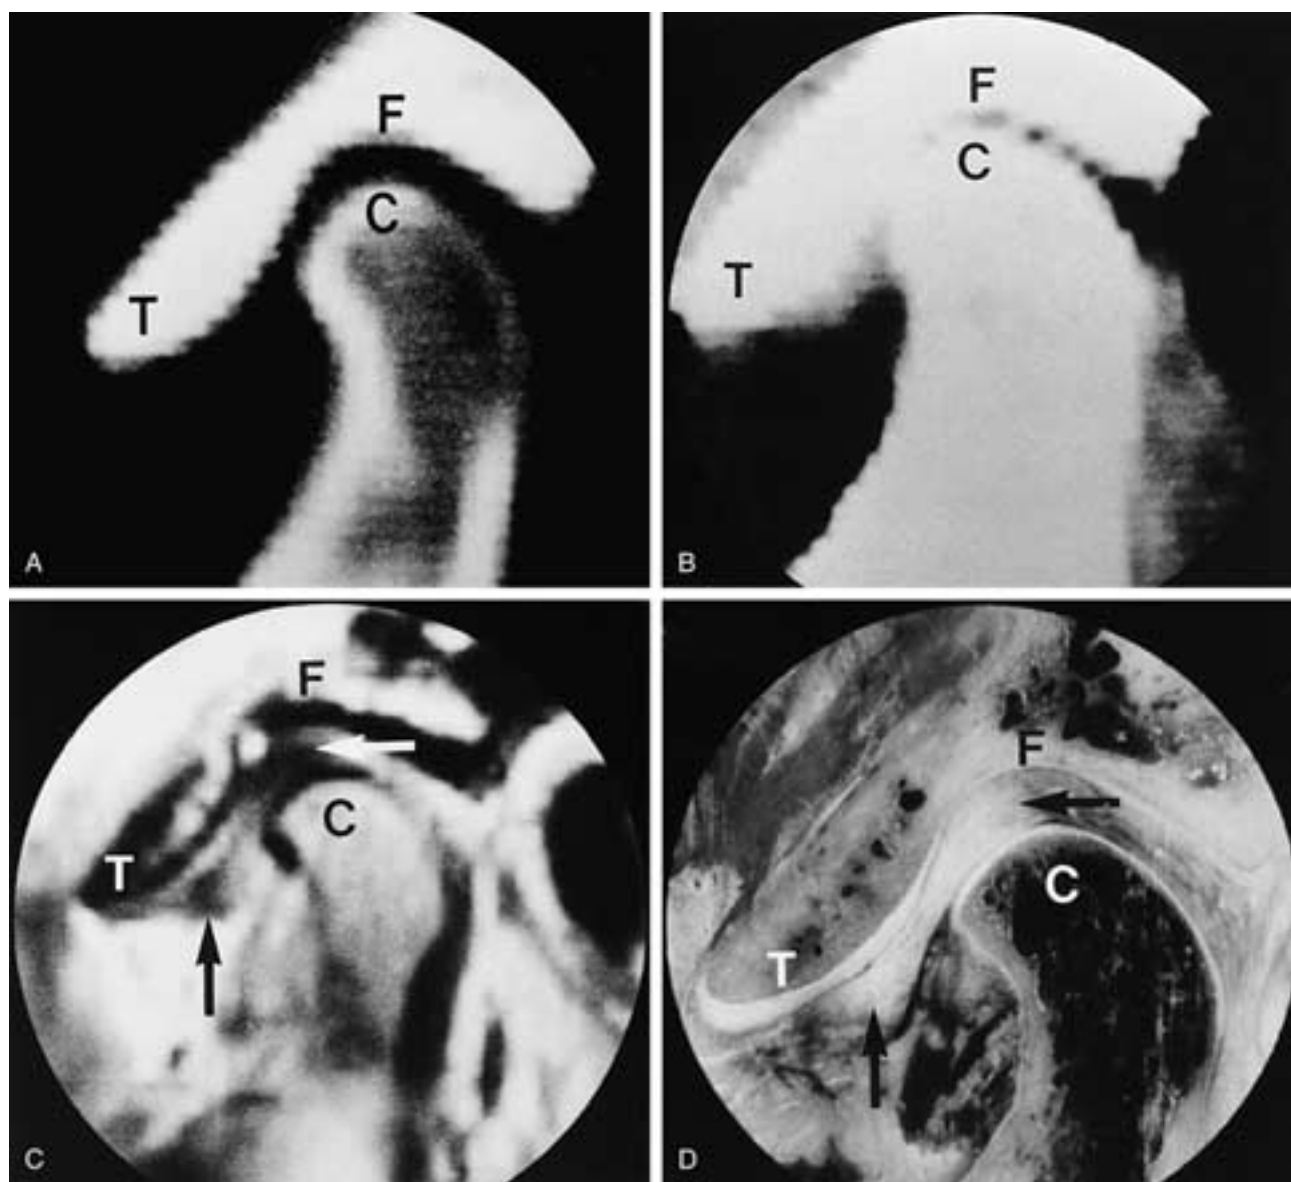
CT in hard-tissue (A) and soft-tissue (B) settings, MR imaging (C), and corresponding cryosection (D) of a TMJ with the normal superior disk position. The tubercle (T), fossa (F), and condyle (C) are indicated. The anterior and posterior bands of the disk are indicated by arrows.
